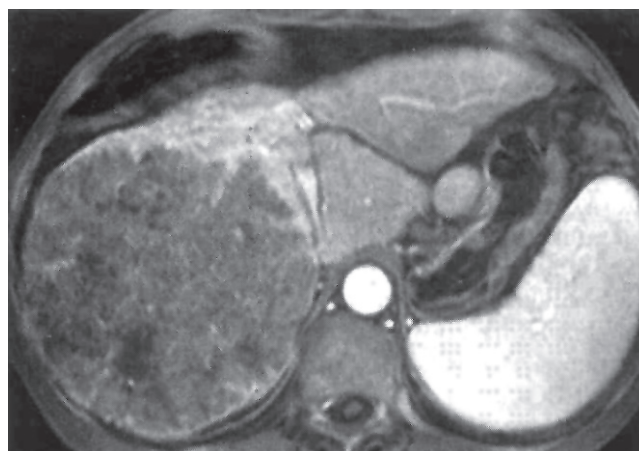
MRI: Hepatocellular carcinoma
